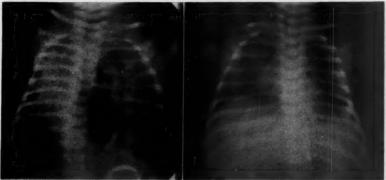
A. (Left hand side) Preoperative roentgenogram of a new born infant with a congenital Foramen of Bochdalek hernia on the left. The left hemithorax contains herniated stomach and intestine. There is severe mediastinal shift to the right and marked compression of the right lung. B. (Right hand side) Postoperative film on same child shown in figure 6A.
